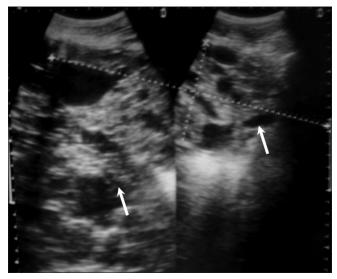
Abdominal sonogram showing multiple noncommunicating anechoic cystic lesions within the left kidney (upper and lower poles) causing destructive compression of the kidney parenchyma (white arrows)
